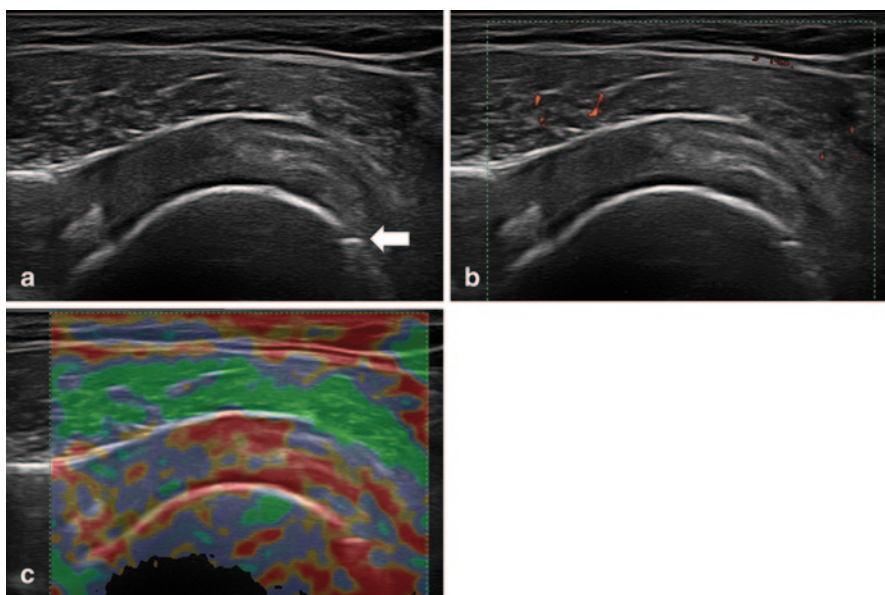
(a) Supraspinatus tendon 2 years postsurgical repairing, the image is in longitudinal view and gray scale exhibit as hypoechoic blurred structure. (b) Doppler signal is located in the muscle. (c) Elastography shows a marked red area in the zone of the repair (*soft*); an anchor is located distally (*arrow*).
